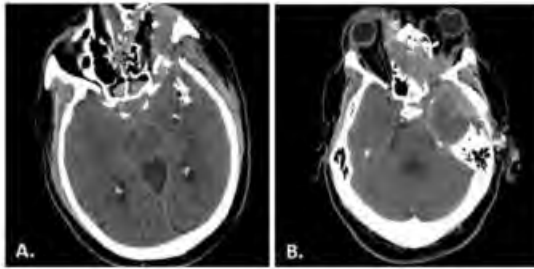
(A) axial head CT shows penetrating gunshot injury involving the left orbit and middle cranial fossa with multiple bullet and bony fragments. No exit wound vs. (B) axial head CT
